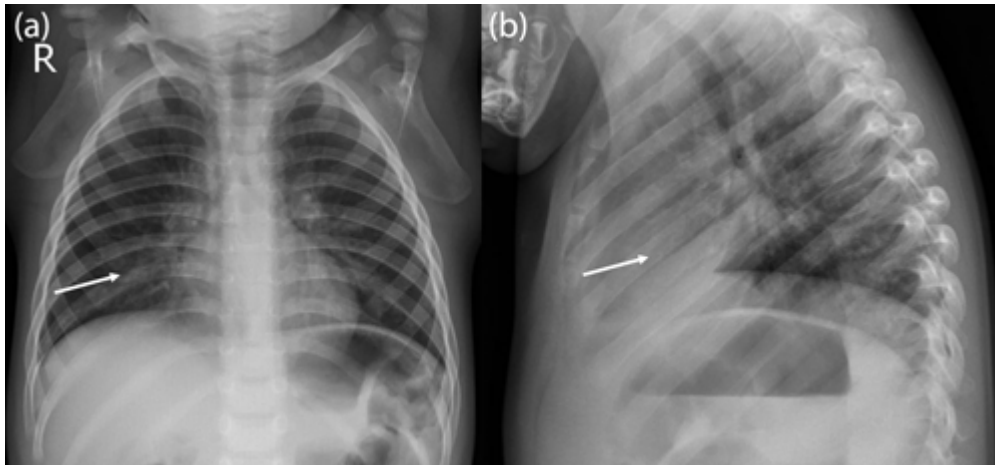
(a) Anteroposterior and (b) lateral chest radiographs taken at 2 months on treatment following acute respiratory deterioration, showing bilateral perihilar infiltrates and improving right hilar/subcarinal nodes with new right middle lobe infiltrates (arrows), clinically suspected to be due to superimposed viral infection. ↩
